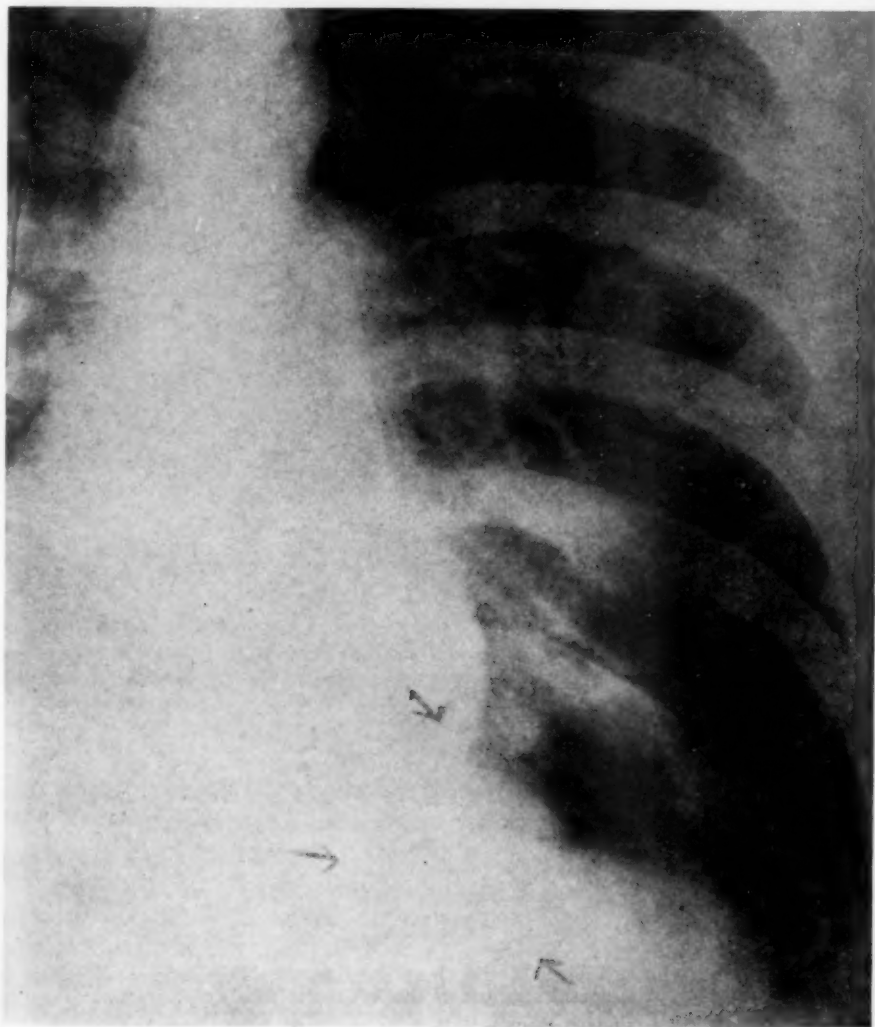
Case 3. PA roentgenogram of the chest showing two round opacities at the left base, representing pulmonary "hemangiomata."
